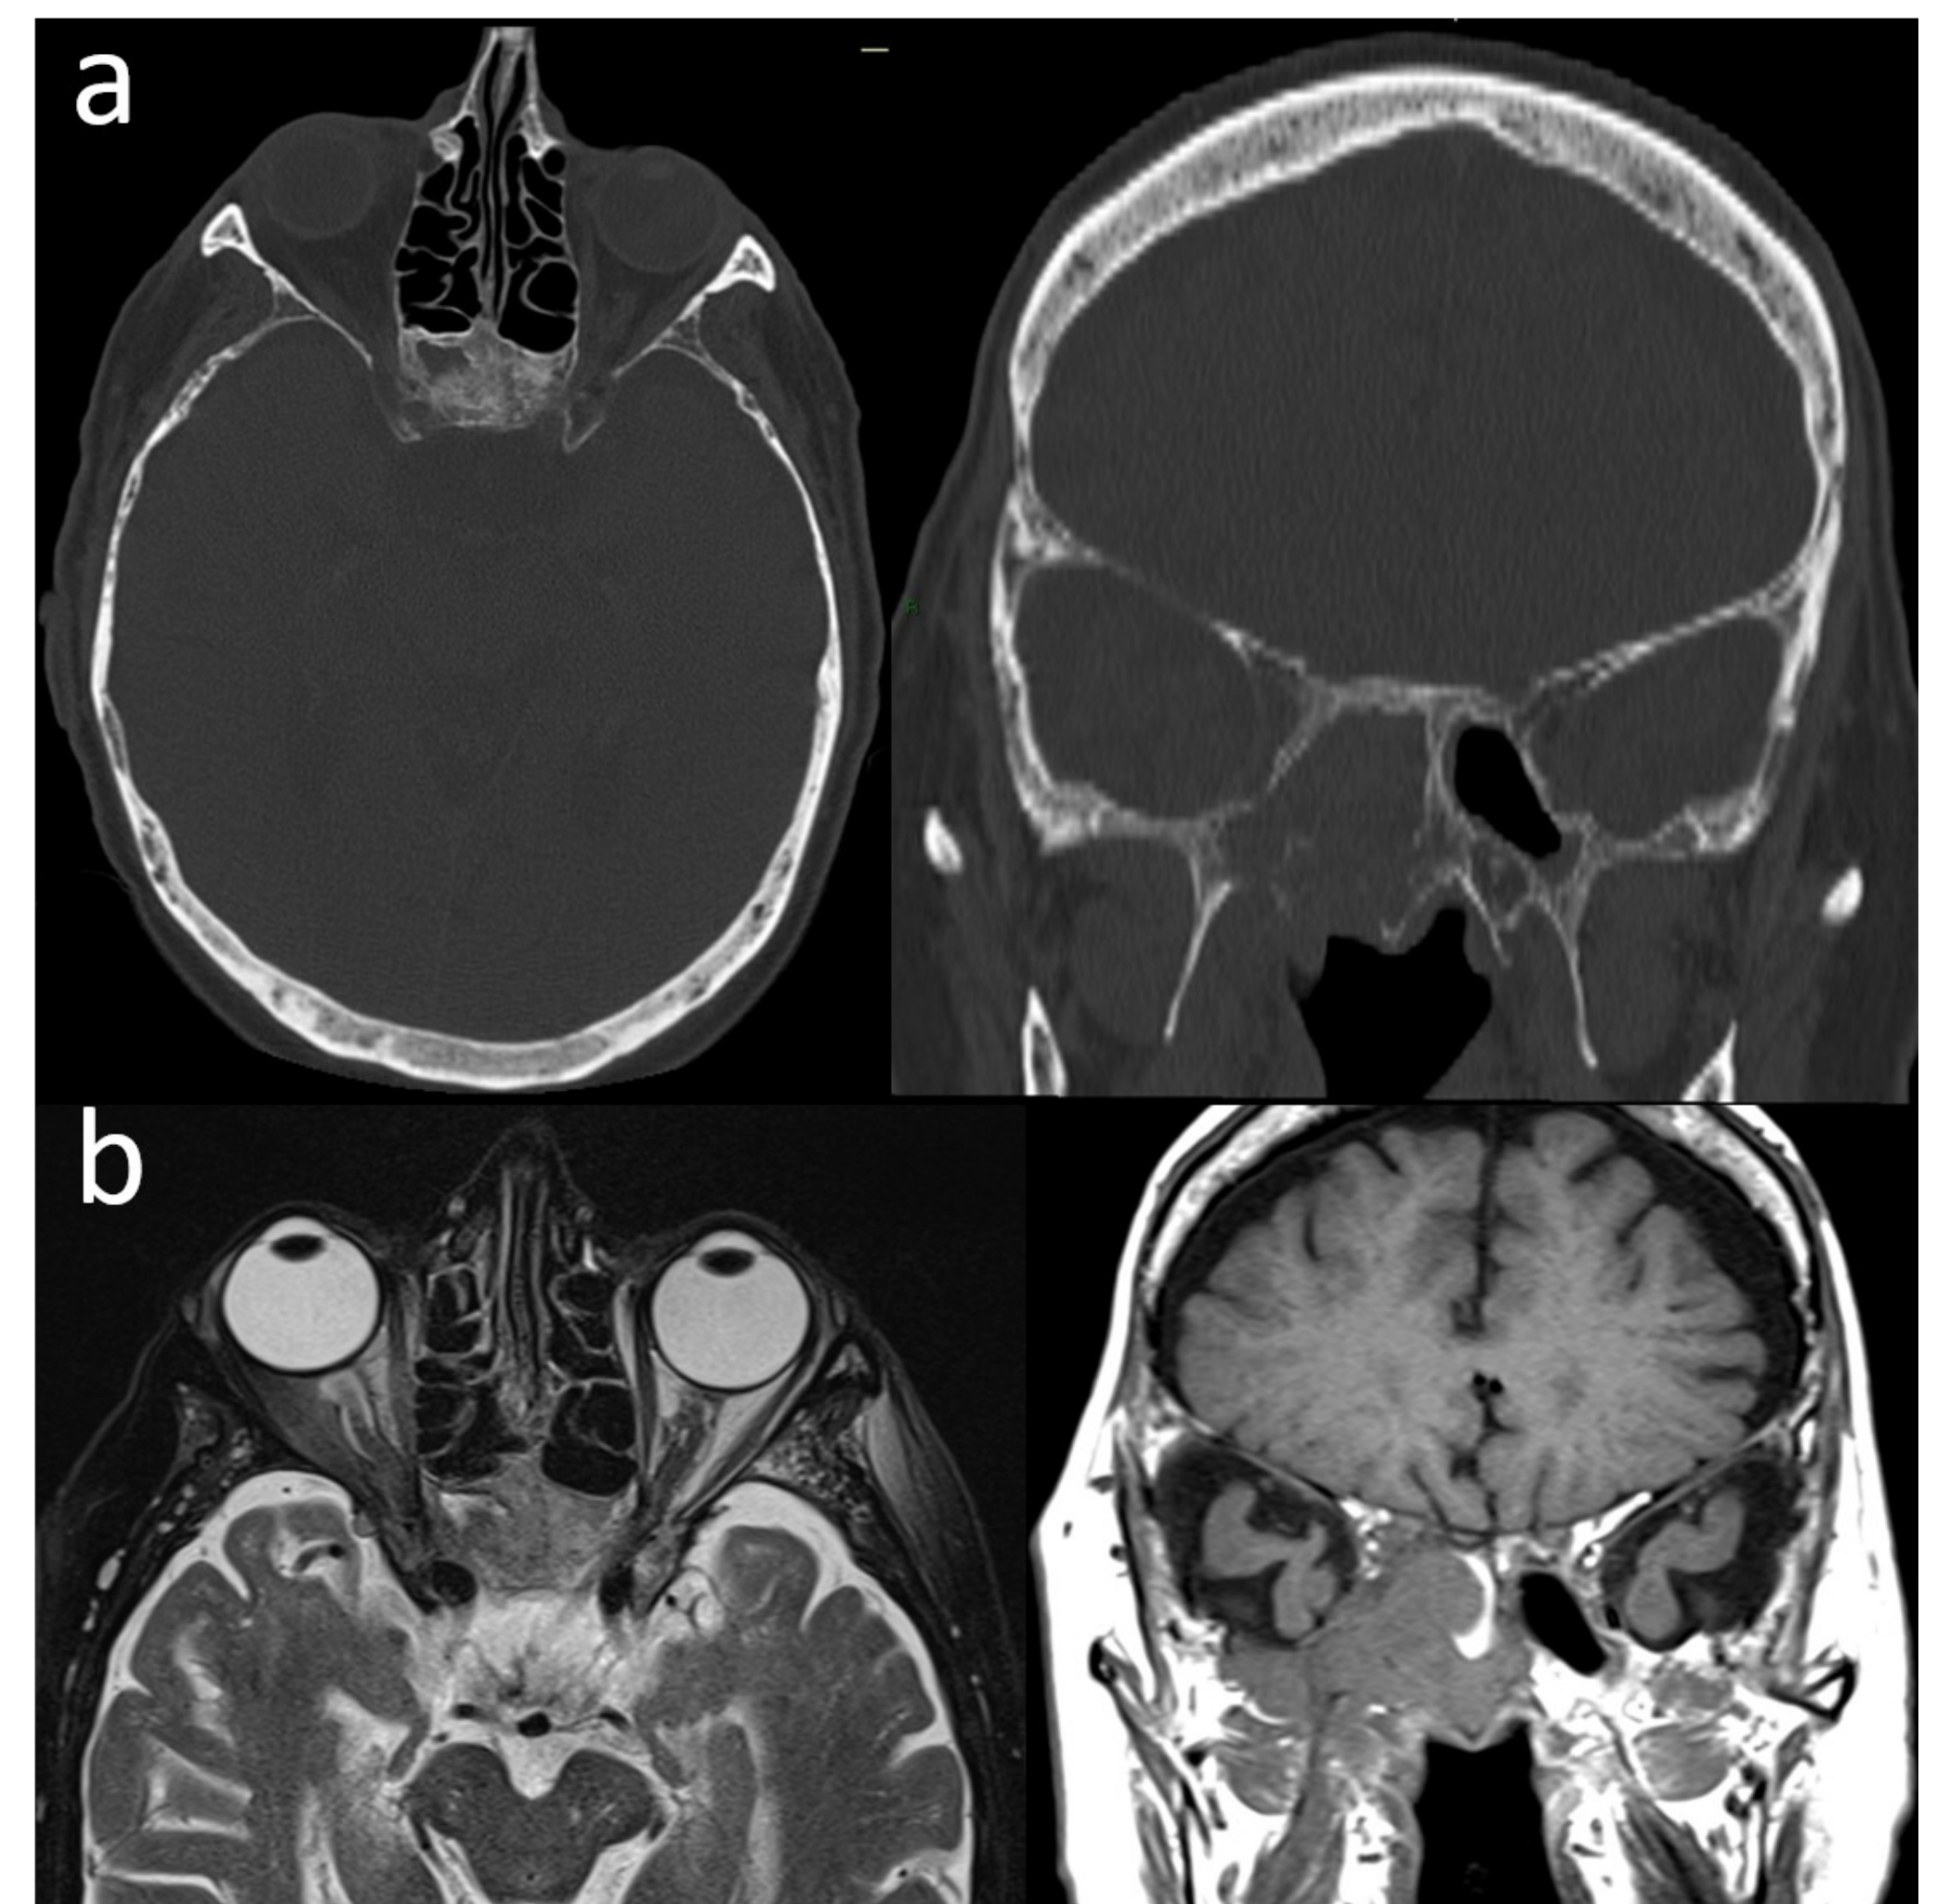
CT scan: axial and coronal reformatted images. Fig. 1b, MRI T2-weighted axial and T1-weighted coronal images.
